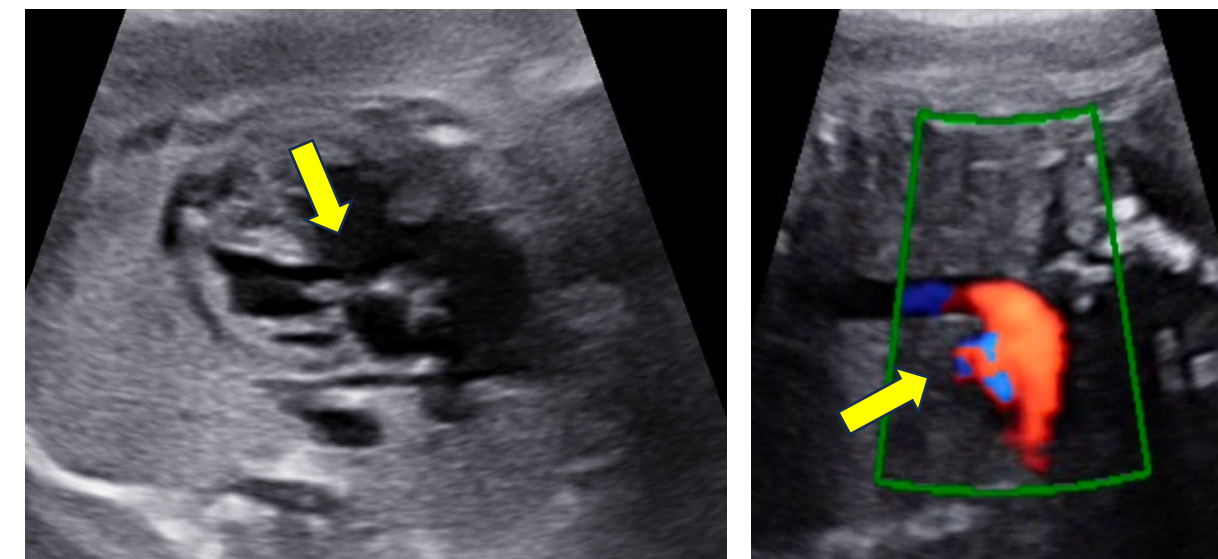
Fetal echocardiography. Two-dimensional scan of the four-chamber view of the heart showing a complete atrioventricular septal defect, transitional type at 23 weeks. Figure 3B. On color Doppler, the flow across the ductus is reversed from the aortic arch (Ao) toward the pulmonary arteries.
